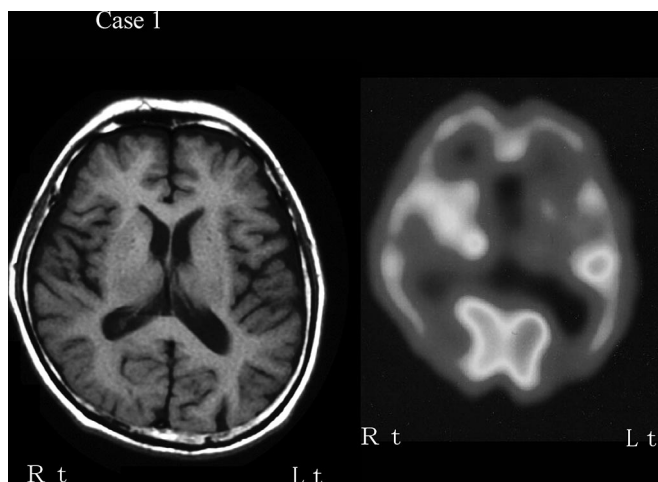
MRI and SPECT findings of case 1. Left: T1-weighted MR image (TR/TE = 300/14.0 milliseconds). Right: ECD-SPECT.
